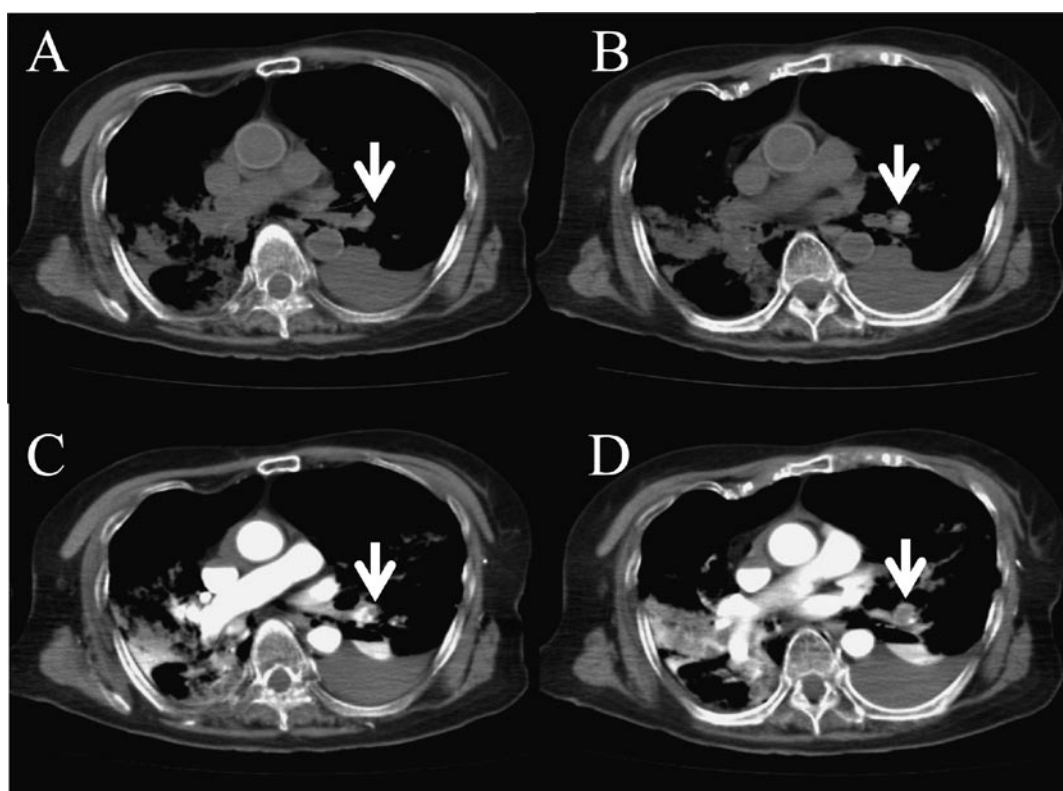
(A and B) Transverse plain computed tomography (CT) showing equivocal pulmonary thrombus. (C and D) Contrast-enhanced CT scan clearly demonstrating filling defects (arrow) in the left lower pulmonary artery with associated thrombus.
